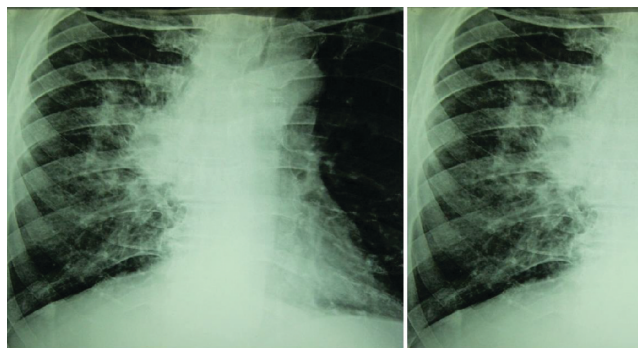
Chest X-ray PA view showing right hilar opacity with linear spreading margins and edges typical of the “sunray sign.”
